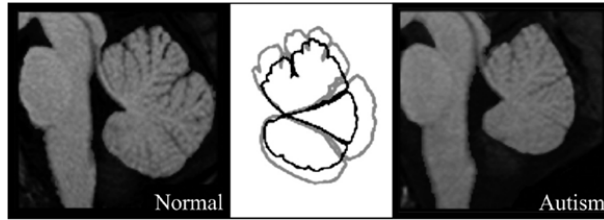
Midsagittal T1-weighted MR images from a representative normal control subject and an individual with autism. Superimposed tracings highlight the difference in midsagittal vermis area between these two individuals [3].*
